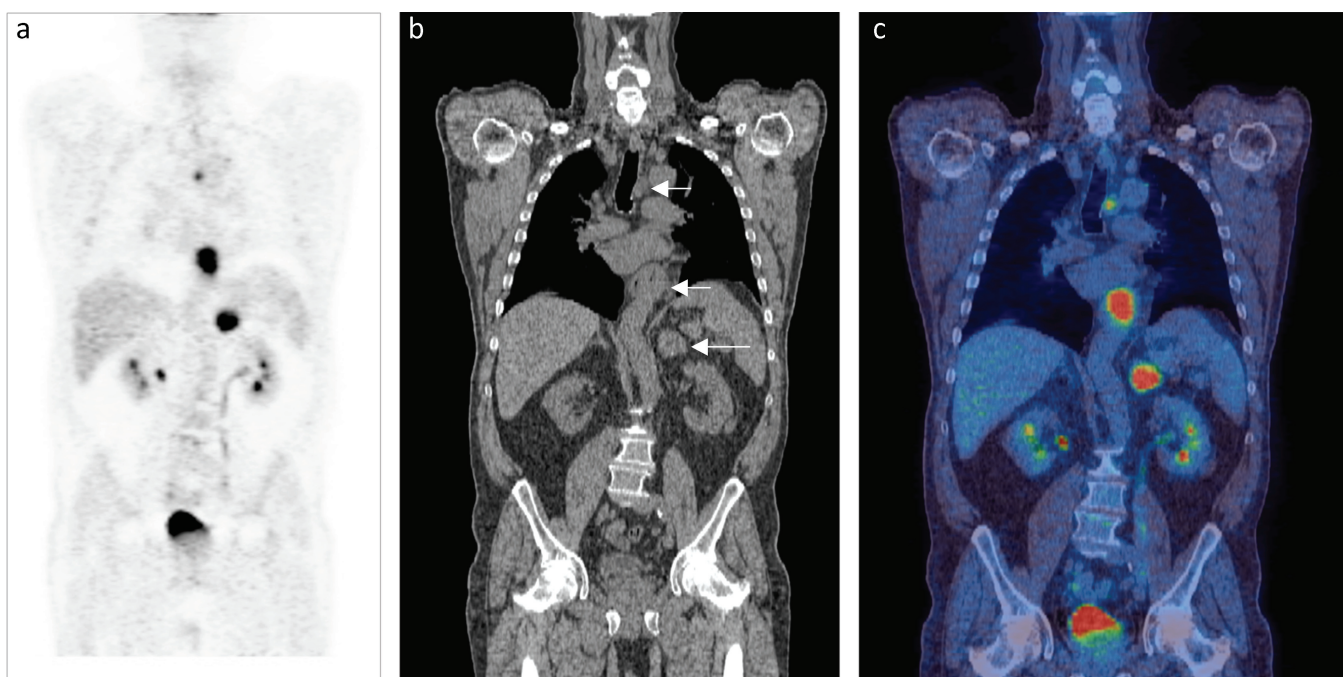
Oesophageal cancer. Coronal ^{18}F -FDG images show intense abnormal activity in a left paratracheal lymph node (top arrow), distal thickened oesophagus (middle arrow) and a left adrenal metastasis (bottom arrow).
